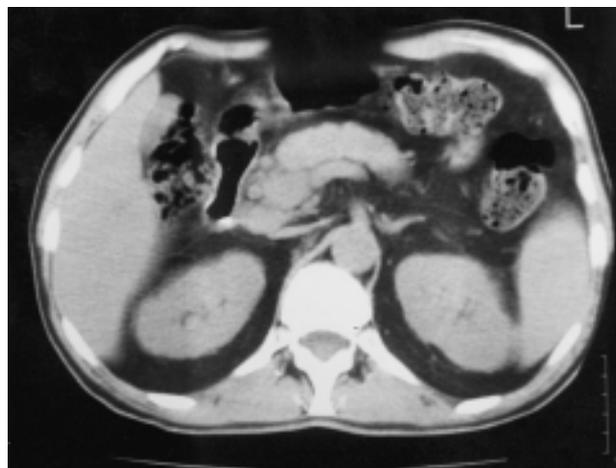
CT scan revealing enlargement and anomogeneity of the head of the pancreas.
